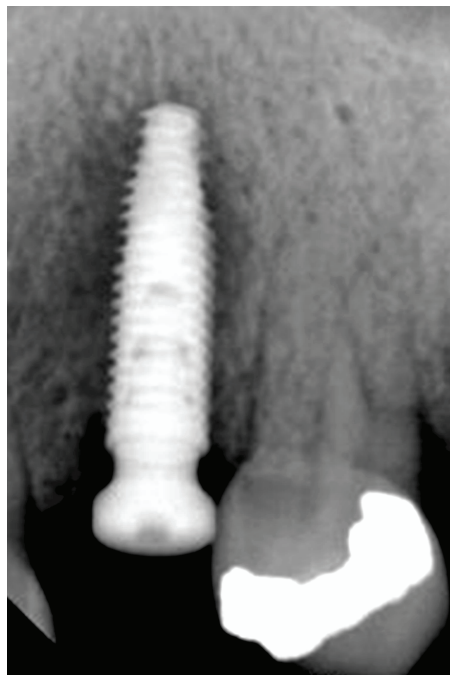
Radiograph of the implant in the posterior left maxillary premolar site at 8 months post placement and unloaded demonstrating peri-implantitis at the apical half of the implant with no noted bone loss at the crestal half of the implant.
